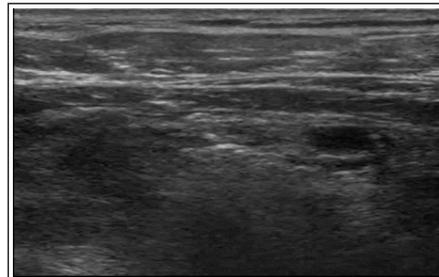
Ultrasound infraclavicular depicting the sonoanatomy with a curvilinear probe.
